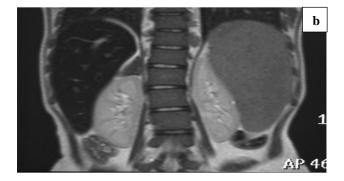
Coronal T2-weighted MRI image shows dark hepatic right adrenal signal intensity.
